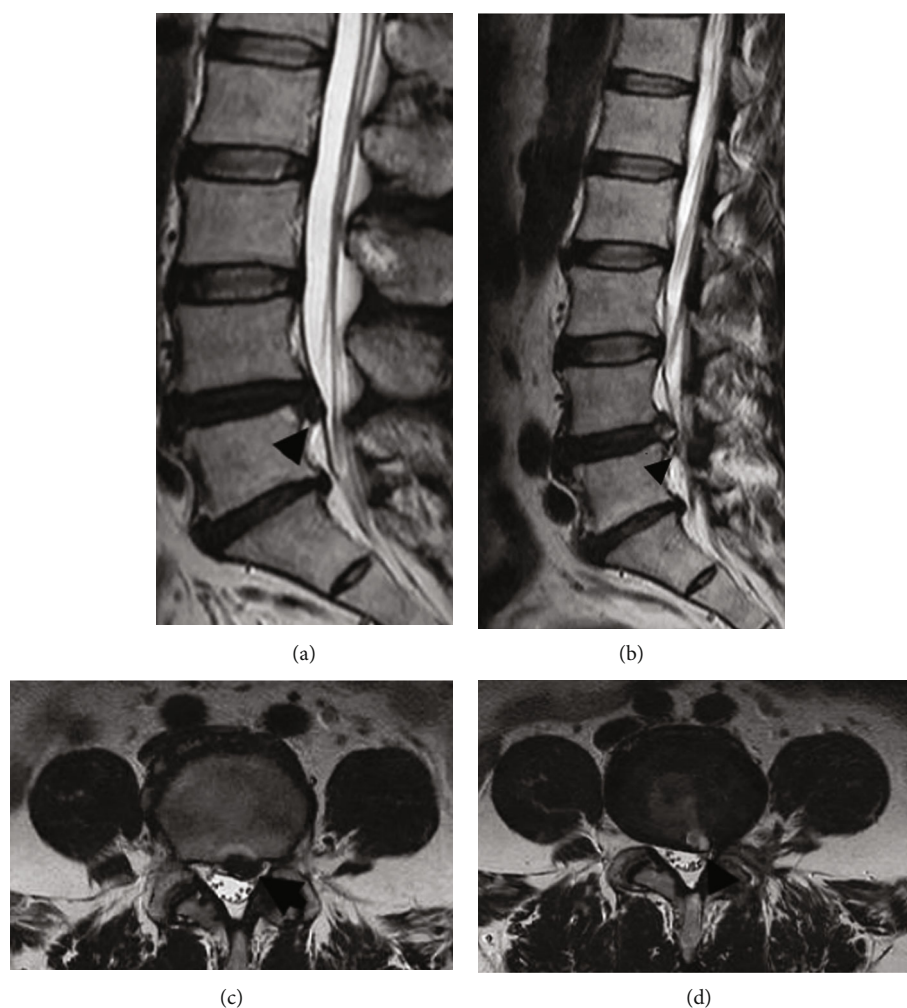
MRI imaging of typical case 1 (a: MRI sagittal of L4. Five intervertebral disc herniation before operation; b: MRI sagittal of L4. Five intervertebral disc after prolapse poroscopy; c: coronal MRI of L4. Five intervertebral disc herniation before operation; d: coronal MRI of L4. Five intervertebral disc herniation after prolapse poroscopy.).
